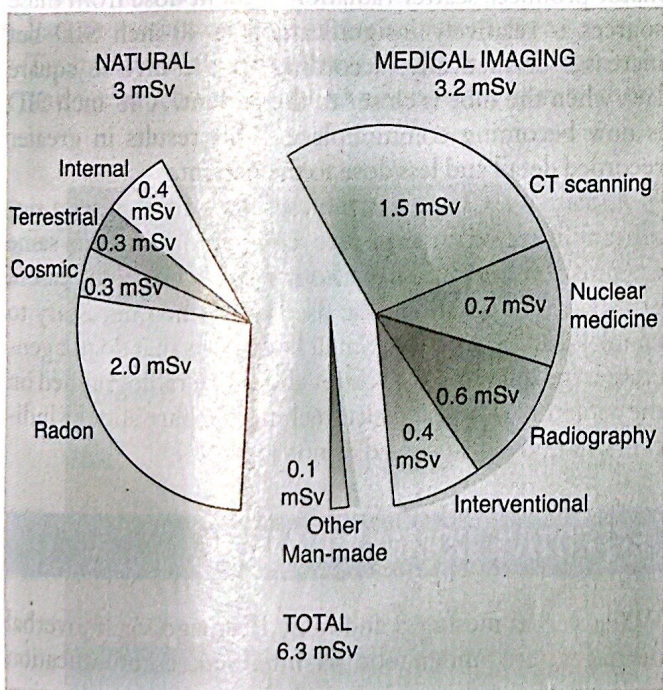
Current estimated levels of human radiation exposure. For the first time, medical imaging exposure values have exceeded natural background exposures. *CT*, Computed tomography.
